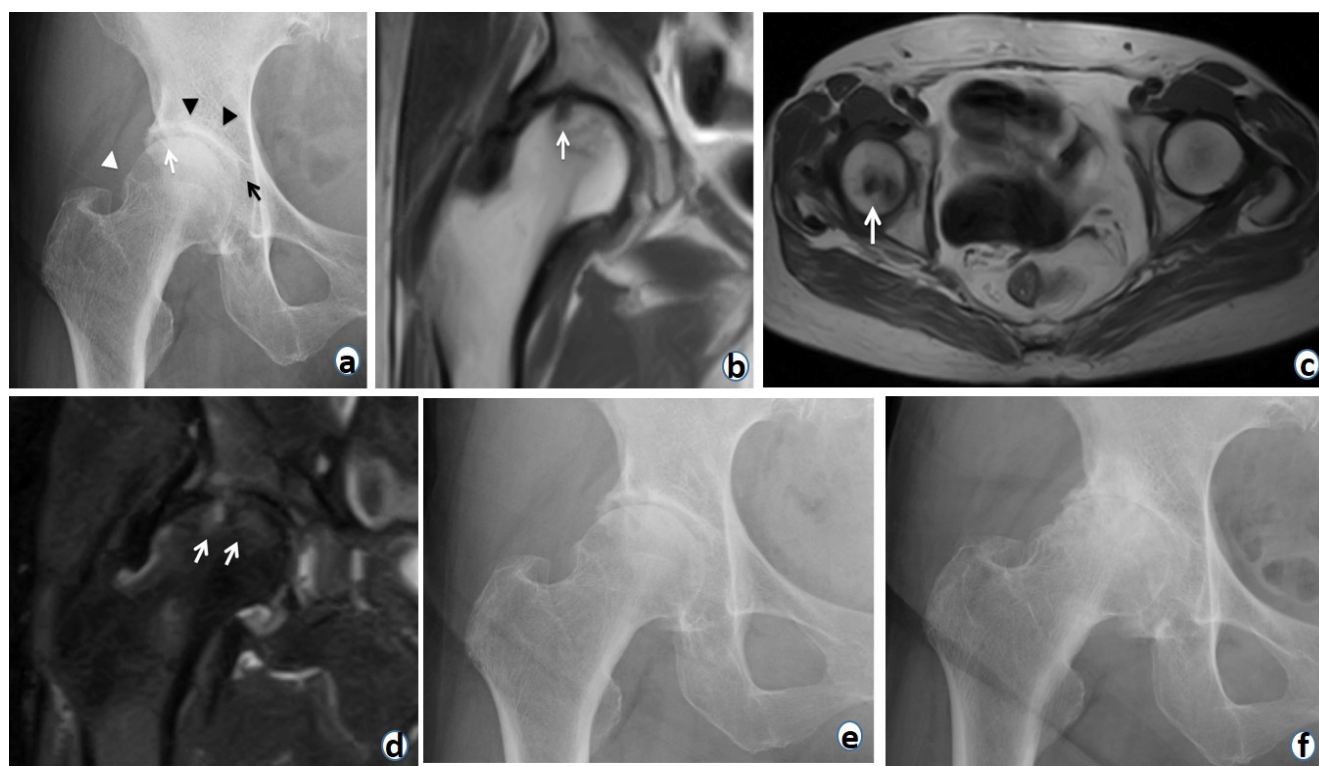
X-rays and magnetic resonance imaging (MRI) images of the second subchondral insufficiency fracture (SIF) (a) X-ray obtained 5 months after disappearance of the first hip pain shows a 1-mm collapse at a lateral site on the femoral head (white arrow) and an osteophyte at the lateral-head neck junction of the femoral head (white arrowhead). The osteophyte on the acetabular fossa (black arrow) and subchondral sclerosis of the acetabulum (black arrowheads) are more clearly observed and the minimum joint space is 1 mm narrower than the observations 5 months previously. Progression of osteoarthritis is observed. (b) Coronal section of a T1-weighted image on MRI at SIF recurrence shows a new low-intensity band at a lateral site on the femoral head (white arrow). (c) Axial section of a T1-weighted image on MRI shows a low-intensity area at a posterior site on the femoral head (white arrow). (d) Coronal section of a T2-weighted image on MRI shows diffuse high signal intensity around the low-intensity band (white arrows). (e) X-ray shows no progressive collapse of the femoral head at 5 months after onset of the second SIF. (f) At 3 years after onset of the first SIF, an X-ray shows progression of osteoarthritis of the hip.
